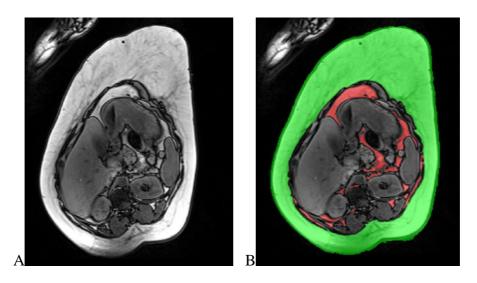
Maternal adipose tissue MRI images Uncoloured (A) and coloured (B) axial slices to show subcutaneous (green) and visceral (red) fat distribution
